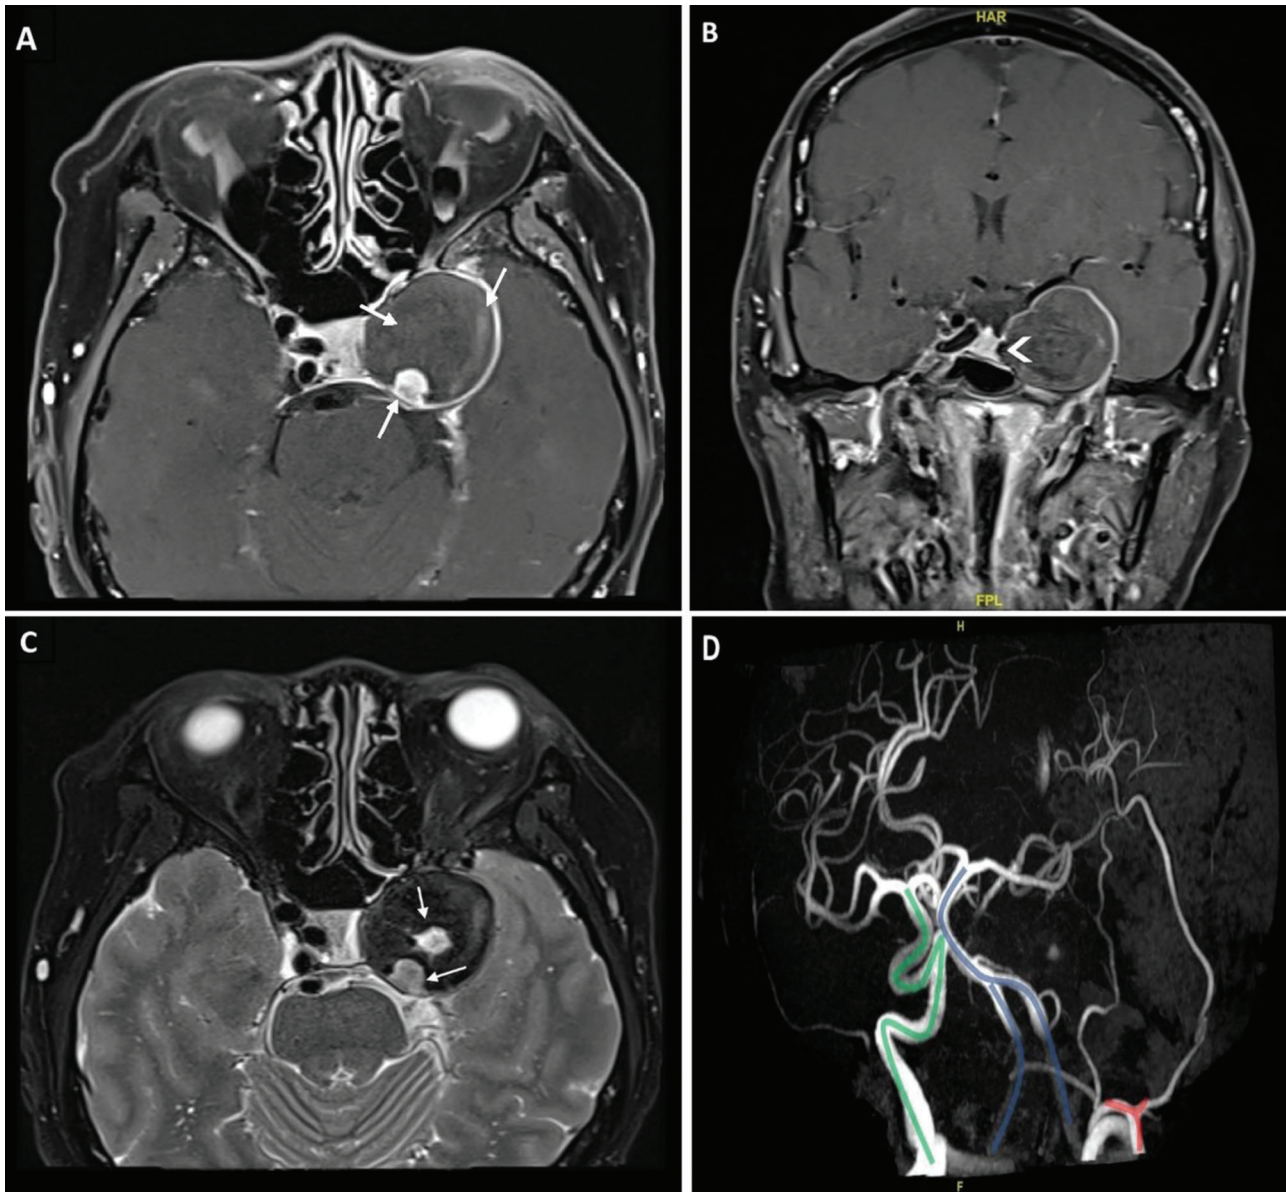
MRI Orbit T1 axial (A) and coronal views (B) with contrast, and T2 axial (C) showing a giant cystic lesion measuring 3.6cmx3.4cm along the course of the cavernous segment of the left ICA (arrowhead), likely representing an aneurysm. The differential signal within the aneurysm likely represents a thrombus of different ages (arrows). (D) MR Angiography showing the right ICA (green highlight), vertebral and basilar arteries (blue highlight) and left external carotid artery (red highlight) with no definite flow within the aneurysm and absent left ICA secondary to thrombosis. No evidence of subarachnoid hemorrhage or other abnormalities on the MRI.
